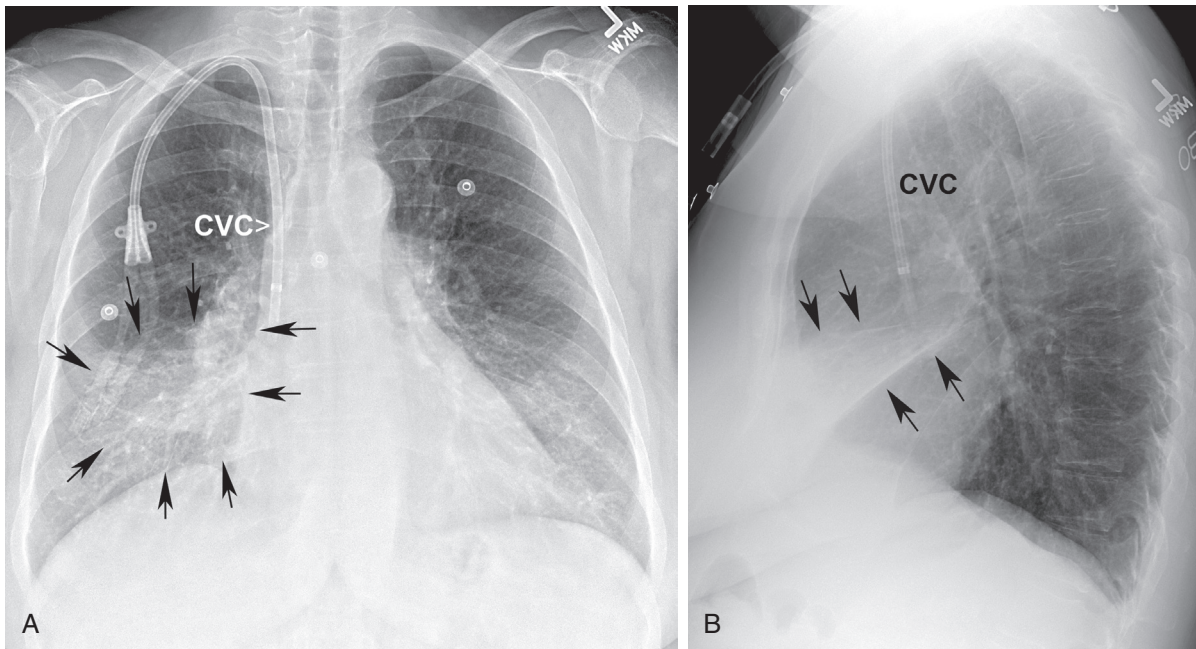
■ A, Posteroanterior (PA) upright chest x-ray. Airspace opacity within the right middle lobe (RML) caused by pneumonia (*outlined by arrows*). Note indistinct right heart margin suggesting the involvement of the medial segment of the RML. B, Lateral upright chest x-ray. Airspace disease located between the minor fissure (*upper arrows*) and the right major fissure (*lower arrows*) caused by a right middle lobe pneumonia.
